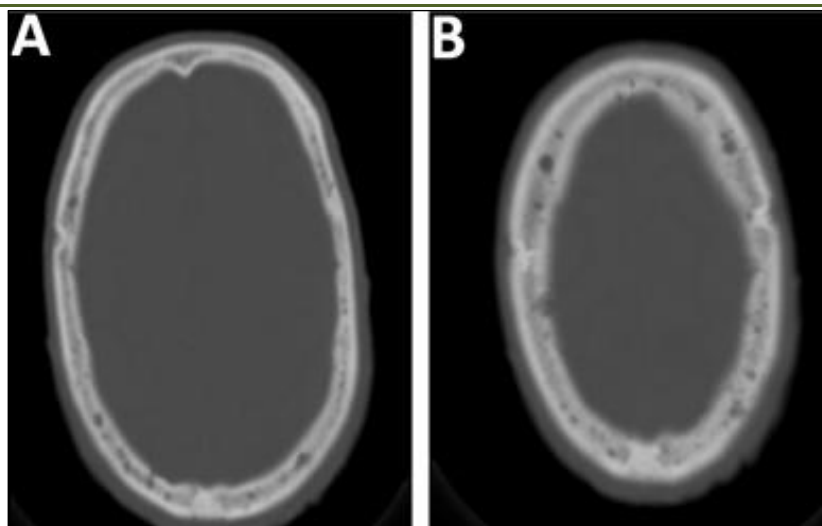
(A)/(B): Computed tomographic scan of the skull revealing multiple lytic lesions
